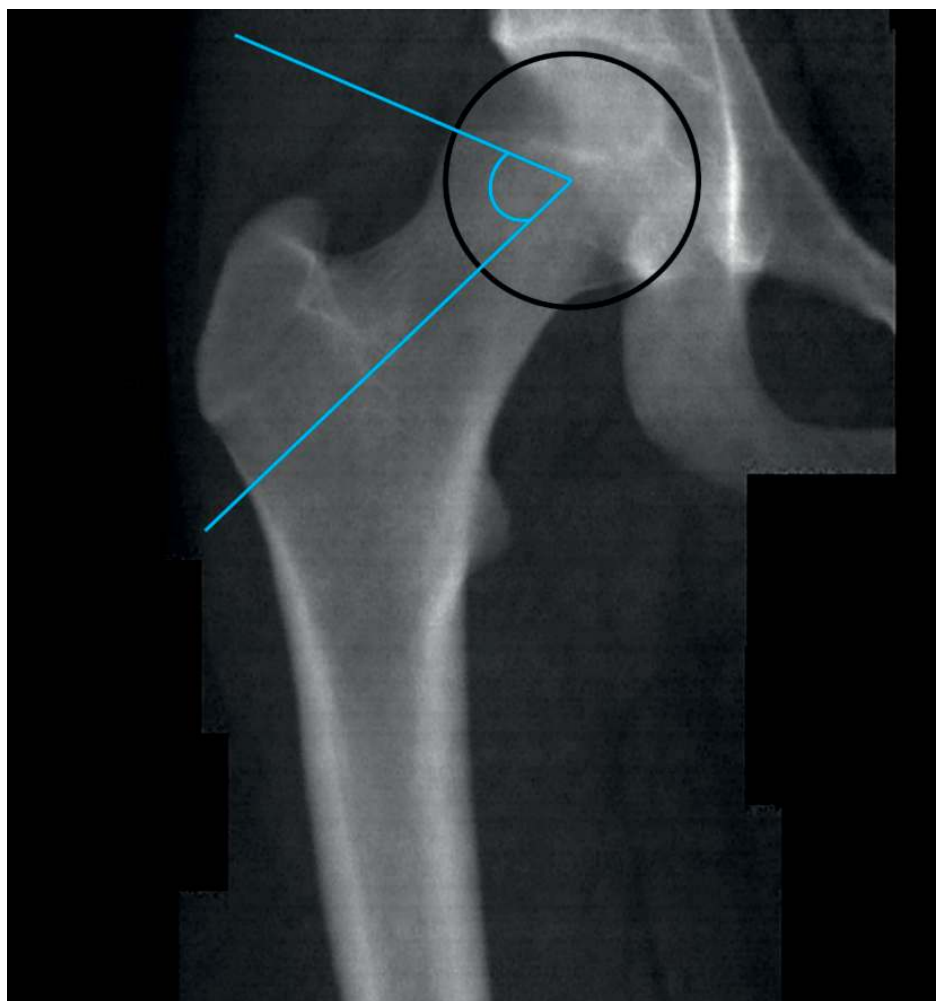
Measurement of alpha angle on a dual-energy x-ray absorptiometry image of the right hip. The alpha angle is formed by the intersection of two lines. From the best-fitting circle center around the femoral head, one line extends to the point where the femoral head first departs from the margin of the best-fitting circle, and the second line extends to the femoral neck center.
